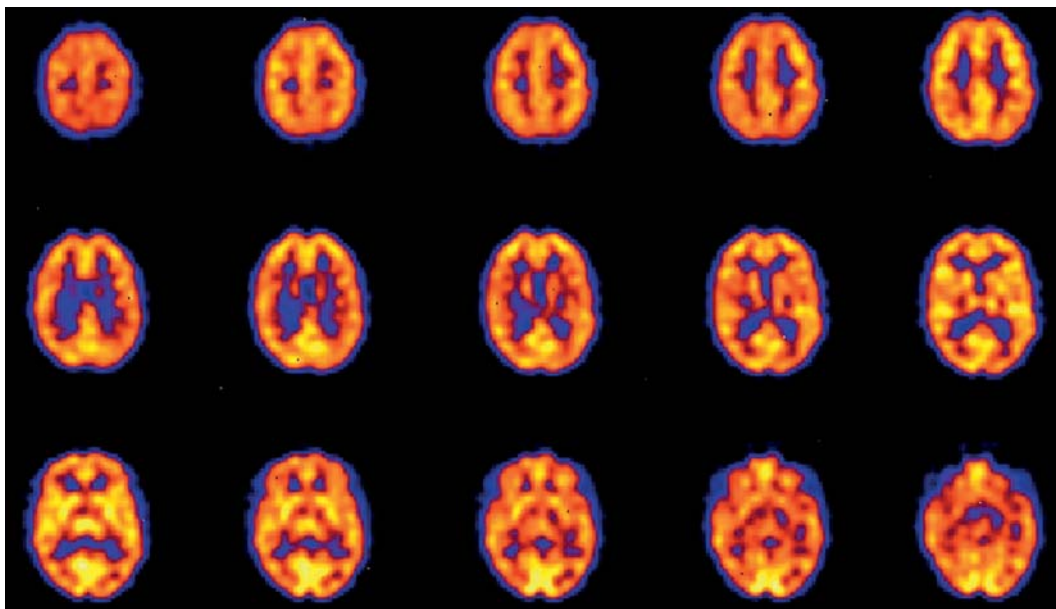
SPECT scan using ^{99m}Tc bismate showing uniform distribution of blood flow throughout the cortical and subcortical structures in a healthy subject. The images are axial slices from the top of the head to the cerebellum.
